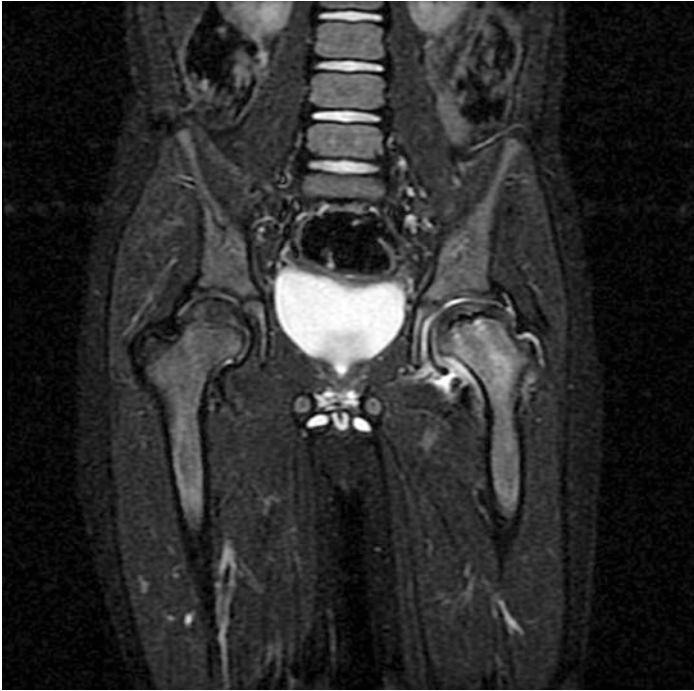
Coronal MRI slice of same pelvis. (Case courtesy of Dr. Ali Abougazia, Radiopaedia.org. From the case rID: 22659)
